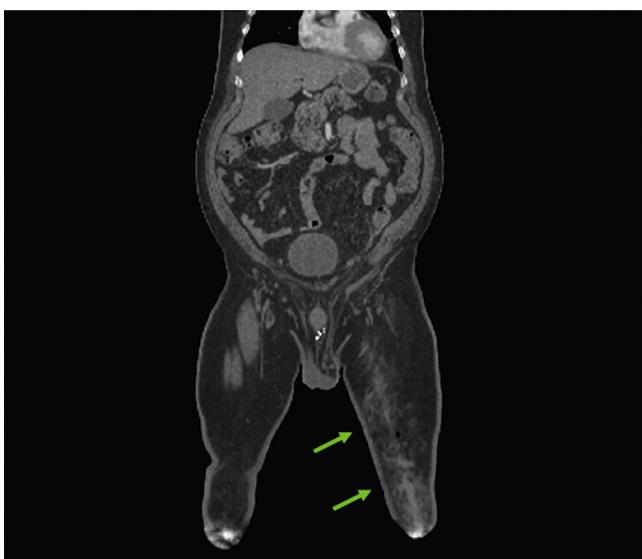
Coronal view of CT angiography shows a bullet tract extending from the anterior aspect of the left knee and travels cephalad up the left lower extremity in the subcutaneous fat (arrows).
